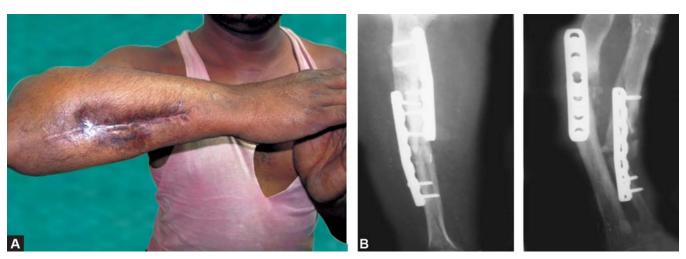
Plain X-ray malunited fractures of both bones forearm
